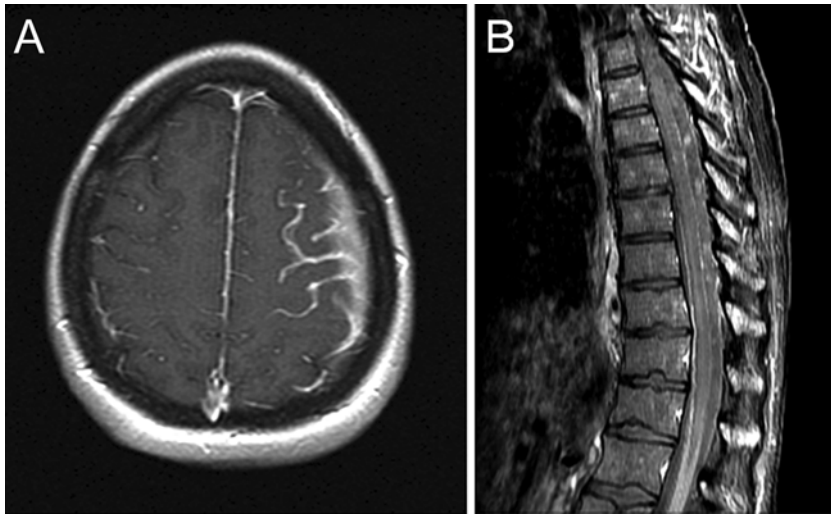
Axial T1 post-contrast brain MRI (a) and sagittal post-contrast spine MRI (b) demonstrating abnormal leptomeningeal enhancement due to leptomeningeal metastasis
